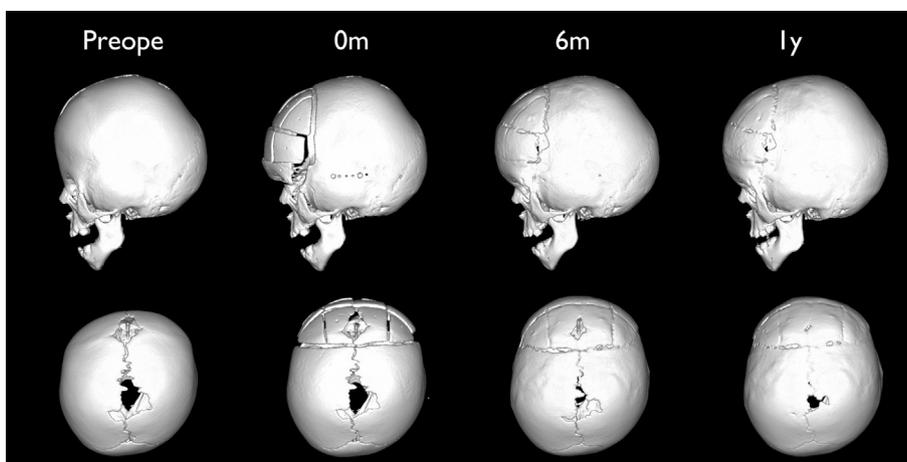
Pre- and postoperative three-dimensional computed tomographic images of Patient 3.
